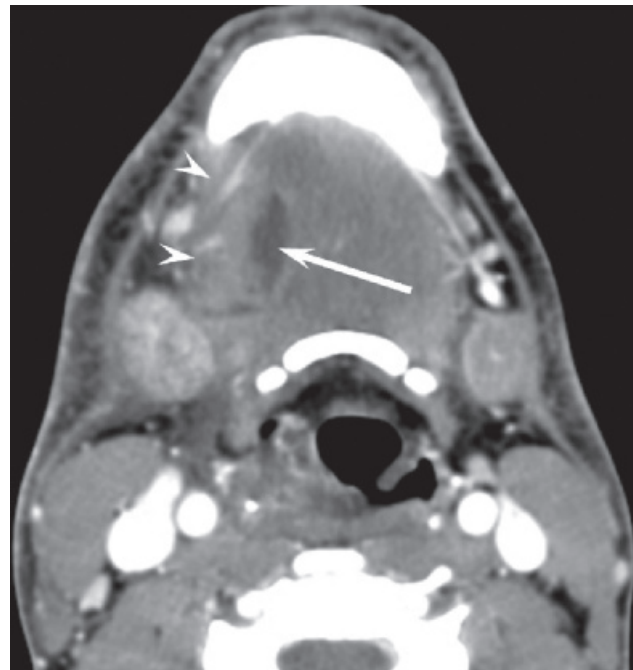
Submental abscess. Axial contrast-enhanced CT shows an ovoid abscess (*arrow*) medial to the anterior belly of the digastric muscle (*arrowheads*), with copious surrounding edema. Extensive fat infiltration and submandibular gland inflammation are restricted to the right side of the face and neck. Reactive edema is seen even into the right side of the larynx.
